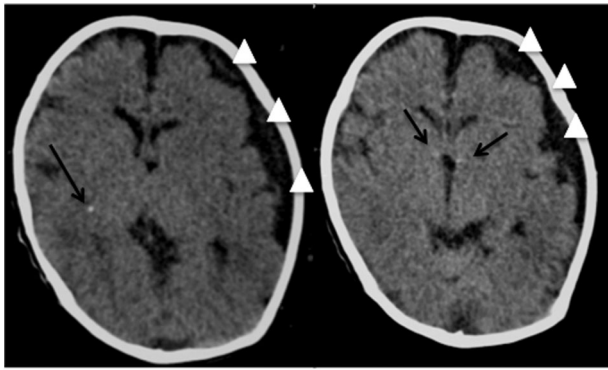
Brain CT at 2.5 months old. White arrowheads pointed chronic subdural hematoma. Spot calcification in posterior limb of internal capsule and bilateral perithalamic regions are indicated by black arrows
